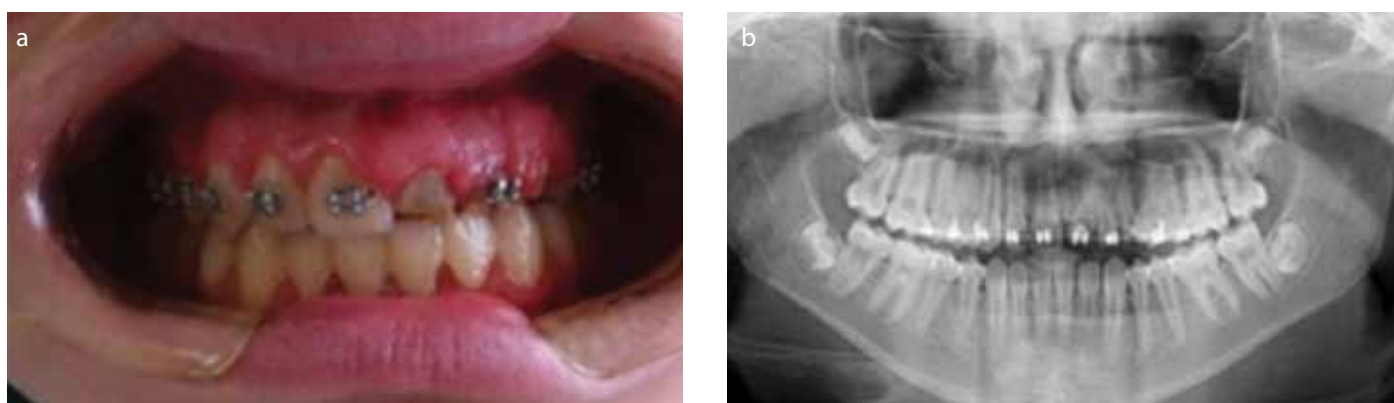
a, b. (a) Intraoral (b) radiographic view during orthodontic treatment.
